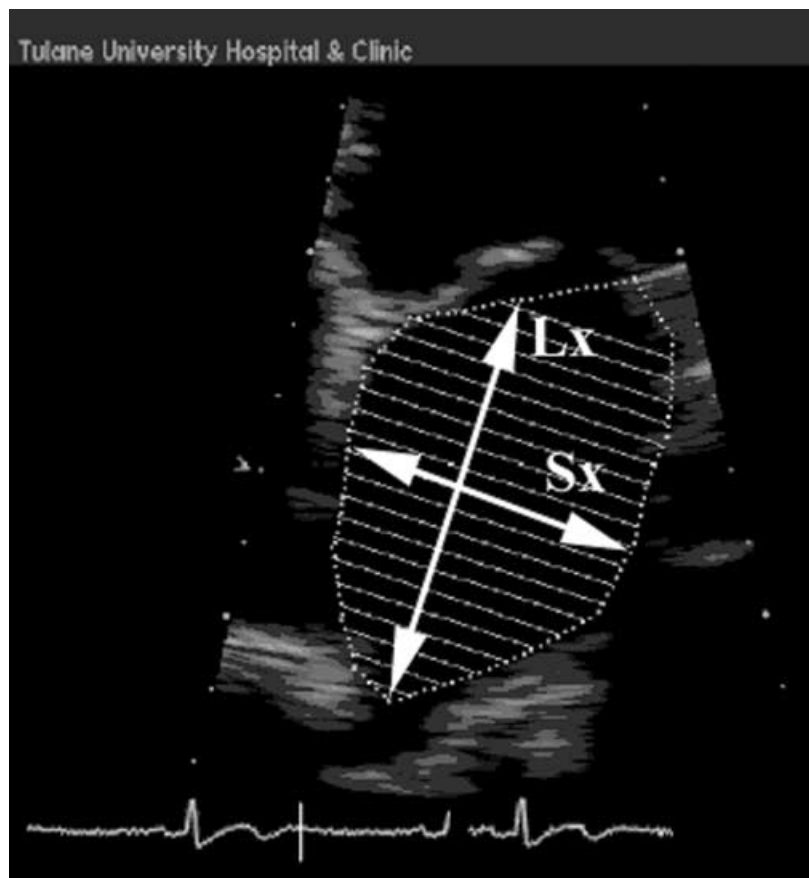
Apical four-chamber view highlighting the LA. The endocardial border has been traced and the area generated, for use by Simpson's Method. One may also use an elliptical model to calculate LAV, in which the LA long-axis (Lx) and short-axis (Sx) are only needed in this view. Tracing an accurate endocardial border may be difficult at times.
